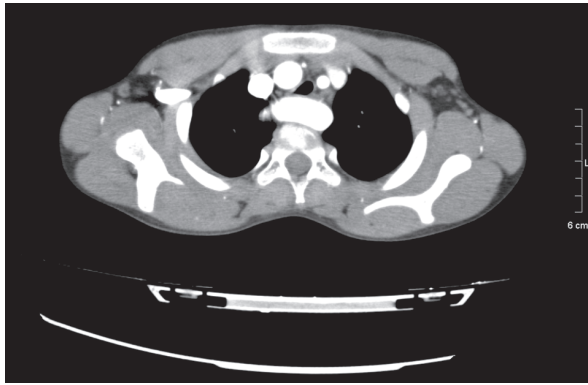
Axial 64-slice multidetector computed tomographic image shows a right aortic arch and tracheal compression.
